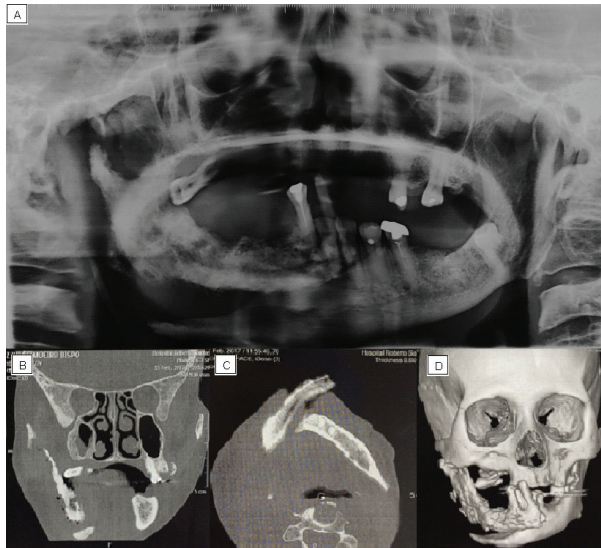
Panoramic radiography with extensive lytic area in right hemi-mandible associated with pathological fracture in symphysis region; 2B. Face tomography with extensive bone involvement and pathological fracture in the symphysis region - Coronal view; 2C. Axial view; 2D. 3D Reconstruction
